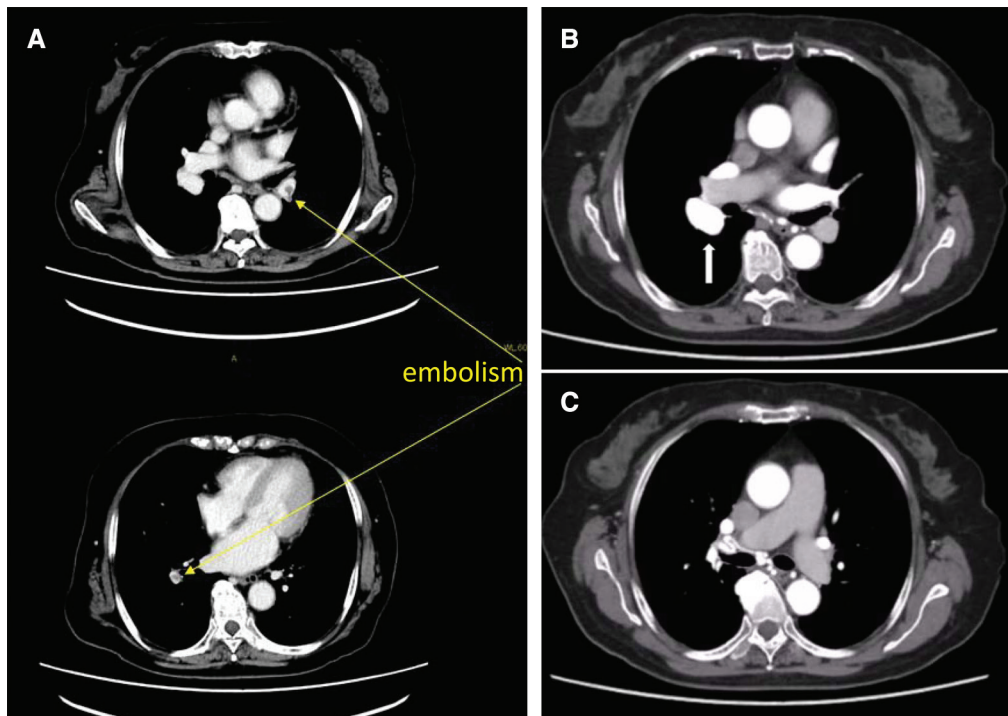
(A) Chest contrast CT showed multiple pulmonary artery emboli that caused her dyspnea. (B) Contrast-enhanced CT showed a huge aneurysm 28 mm in diameter at the right hilum, and (C) there was racemose hemangioma with strong meandering. CT: computed tomography
